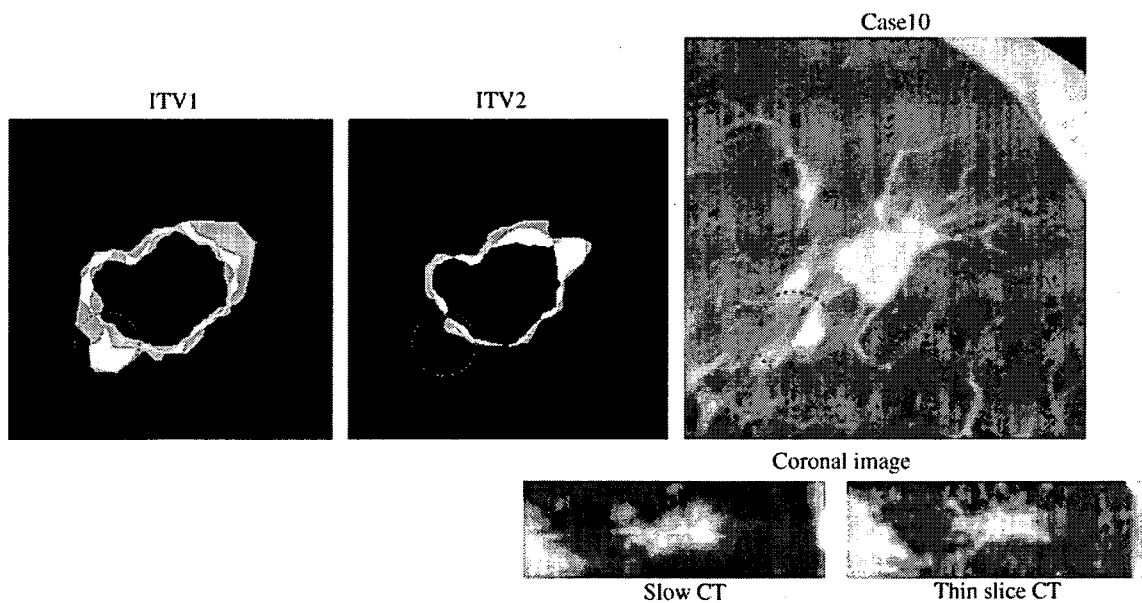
SD-image (ITV1, ITV2) for case 11. The regions with high SD values for ITV1 were excluded from the target delineations by the operators in ITV2. The thin-slice CT apparently revealed this region to be a part of the bronchi.
